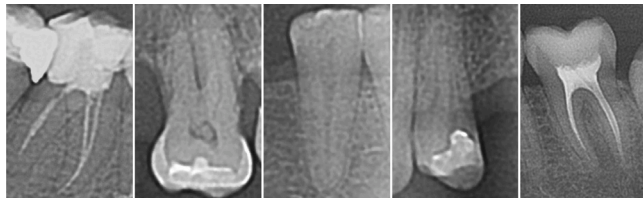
Samples of individual teeth. Individual teeth are clipped from the full panoramic dental X-ray image by their bounding box.
